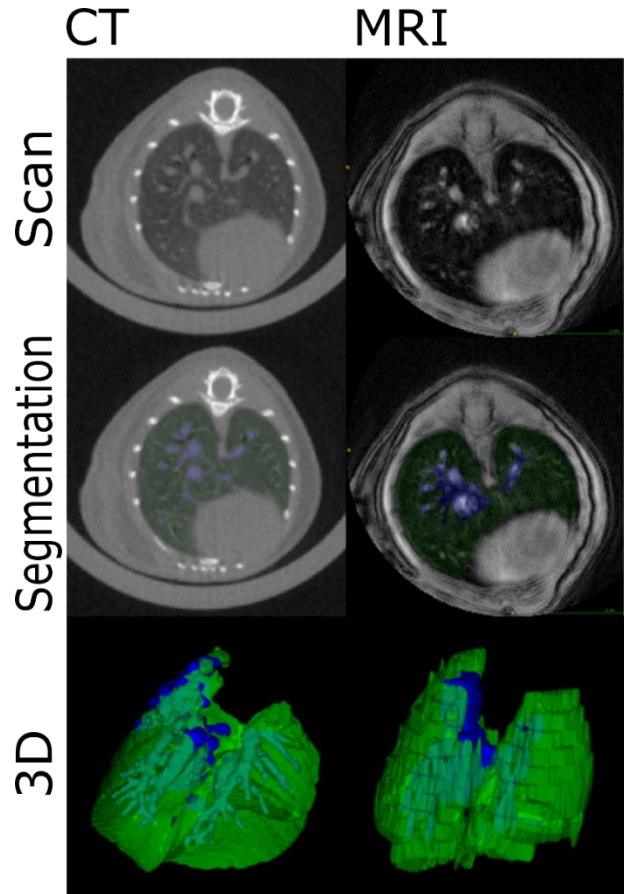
CT and MR scan images, segmentations, and 3D reconstructions. CT shows much greater CNR compared to MRI as well as resolution as can be seen especially in the blocky 3D reconstruction. MR images have worse resolution due to acquiring the scan axially with 1 mm thickness.
